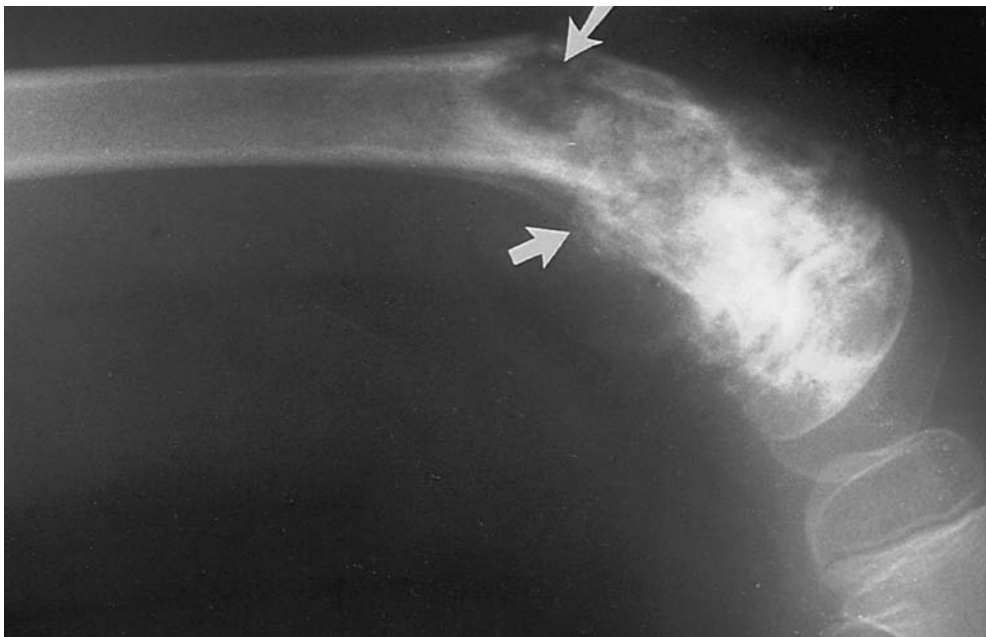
Radiograph of a 5-year-old girl with an osteosarcoma of the left femur showing an acute pathologic fracture (*arrows*). Amputation was ultimately necessary.
